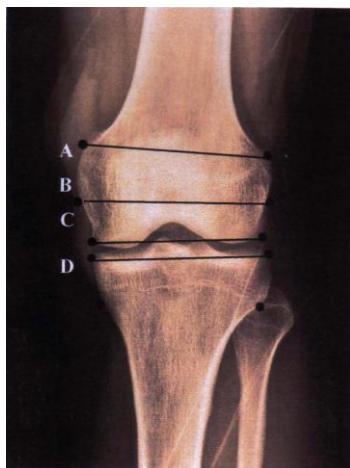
Digital radiograph of the left knee joint anterior- posterior view showing the A- intermetaphyseal distance (IMD), B- interepicondylar distance (IED), C- femoral width (FW), D- tibial width (TW)
